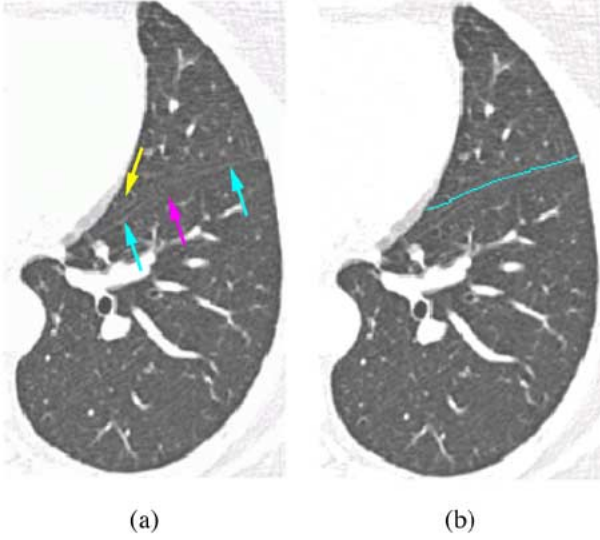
A typical fissure detection error. (a) a original CT image with a blurred fissure (pointed by the cyan arrow) close to the lung boundary. The fissure is too blurred to distinguish in the middle part (pointed by the arrow magenta). Meanwhile, the nearby ridge-like influential structures are presented above the fissure (pointed by the yellow arrow); (b) automatic fissure detection result.
